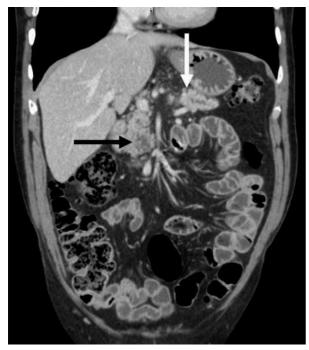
Abdominal CT scan: polycystic lesion in the uncus (black arrow) concomitant with a concurrent stenosis-dilation of the pancreatic duct. A detailed review of the original pancreatic CT scan revealed that the stenosis was caused by a lesion, previously unidentified, corresponding to an independent adenocarcinoma (white arrow).
